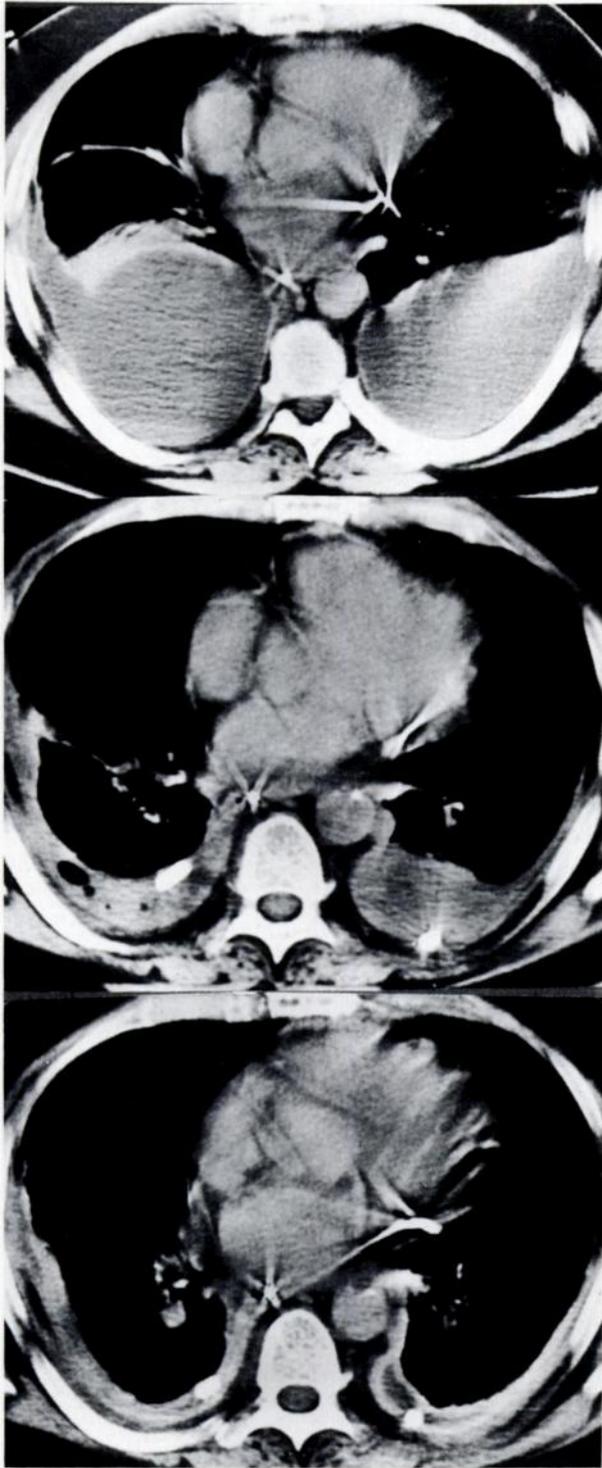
A 55-year-old man is ventilator-dependent and has unstable angina, bilateral pneumonia, and large, complicated parapneumonic exudates refractory to conventional chest tubes. *Top*, CT scan showing bilateral effusions before radiologic guided placement of a 14F drain on each side. Urokinase was given immediately on the right because of the demonstration of numerous septae on ultrasonography and a relatively low initial output of only 300 ml. After an additional output of 700 ml on the right side over the next 24 h, both tubes stopped draining. *Center*, CT scan 48 h later shows significant improvement but still residual fluid, greater on the left than on the right. Urokinase was readministered on the right and given for the first time on the left side. After an
